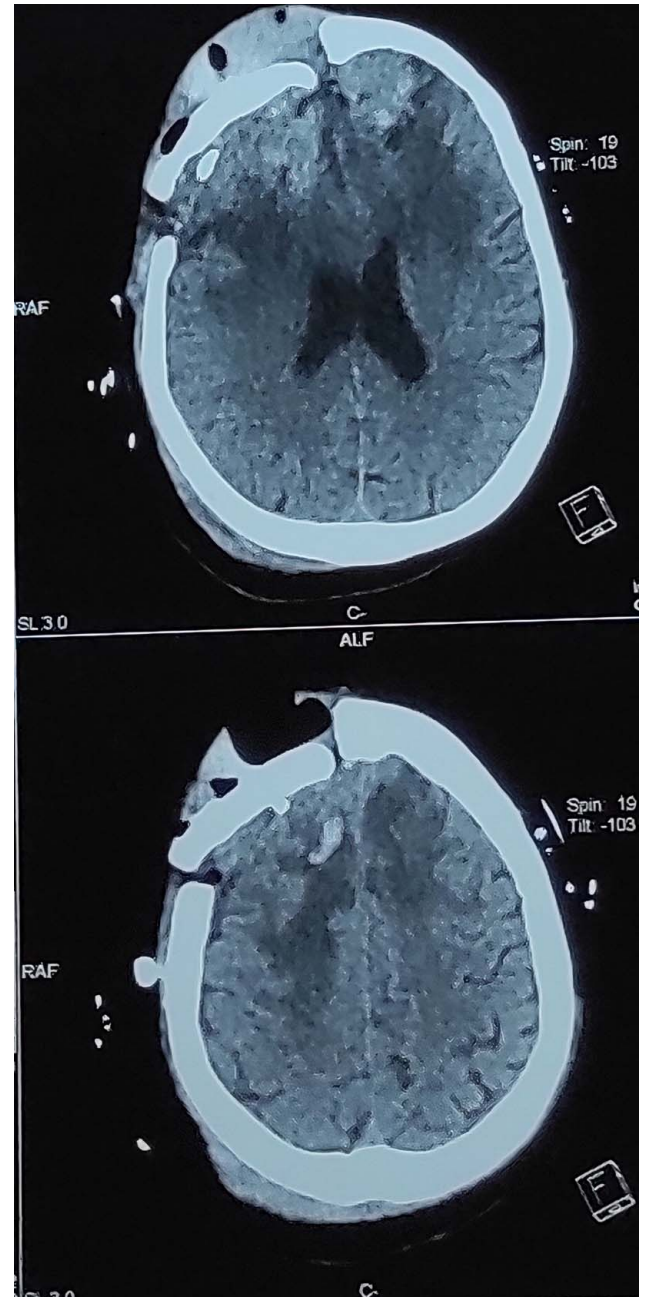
Computed tomography scan showing a recurrent lesion surrounded by significant perilesional edema.
